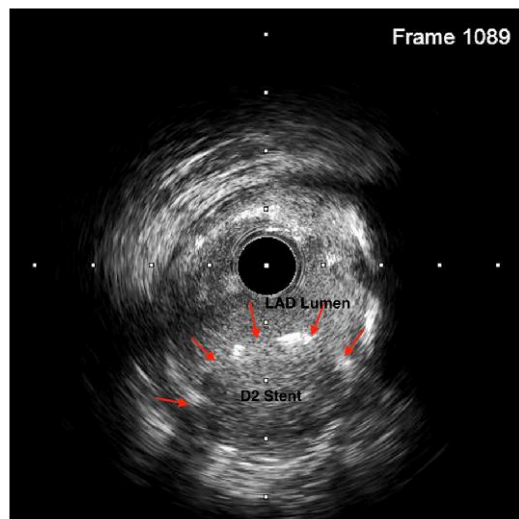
Intravascular ultrasound of the under-expanded mid-left anterior descending artery (LAD) stent at the level of the second diagonal (D2) stent, which extends into the lumen of the main vessel (downward arrows).
